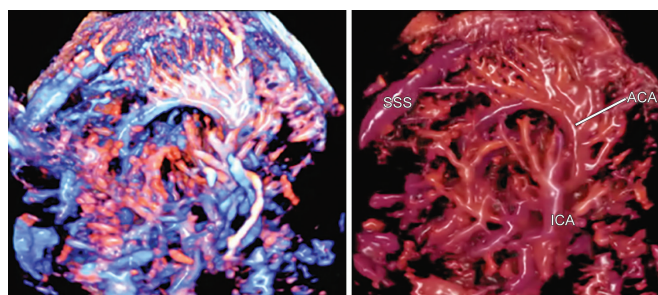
Normal brain vascular structure by HDlive flow imaging at 20 weeks of gestation: Left: Bidirectional power Doppler 3D HDlive flow image of fetal vascular structure, and Right: Mono-color HDlive flow image; (ACA: anterior cerebral artery; ICA: internal carotid artery; SSS: superior sagittal sinus)
